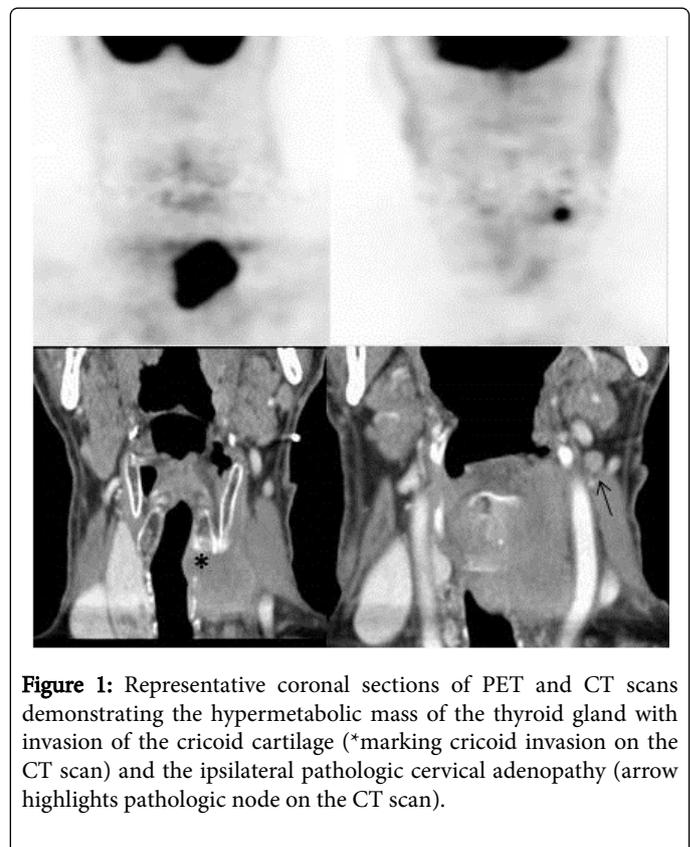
Representative coronal sections of PET and CT scans demonstrating the hypermetabolic mass of the thyroid gland with invasion of the cricoid cartilage (*marking cricoid invasion on the CT scan) and the ipsilateral pathologic cervical adenopathy (arrow highlights pathologic node on the CT scan).
